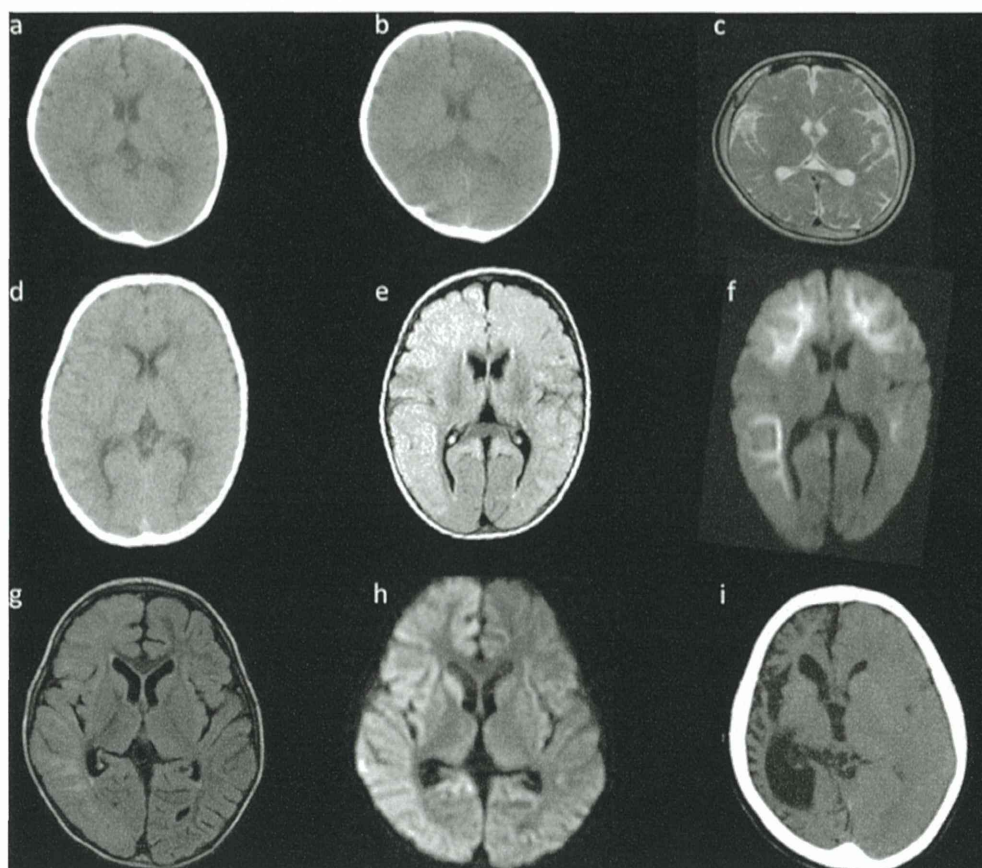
Cranial CT/MRI findings in acute encephalopathy in children taking theophylline (AET). In Case 1, cranial CT on day 3 showed slight narrowing of the cerebrospinal fluid space, but no clear evidence of cerebral edema (a). On day 7, however, CT showed mild narrowing of the cerebrospinal fluid space and hypodensity of the white matter, indicating delayed cerebral edema (b). Seven years later, MRI (T2-weighted imaging) demonstrated diffuse cerebral atrophy with bilateral subdural effusion (c). In Case 6, CT on day 1 was normal (d). MRI on day 7 showed narrowing of the cerebrospinal fluid space and hyperintensity of the bilateral frontal and temporal cortex on fluid-attenuated inversion recovery (FLAIR) imaging, indicating delayed cerebral edema (e). Diffusion-weighted imaging visualized restricted diffusion in the subcortical white matter (bright tree appearance), with sparing of bilateral peri-Rolandic regions (f). In Case 15, MRI in the subacute period (day 28) showed T1/T2 prolongation of the right cerebral cortex ((g) T1-weighted imaging, (h) FLAIR imaging). Two months later, CT showed atrophy of the right hemisphere (i).
